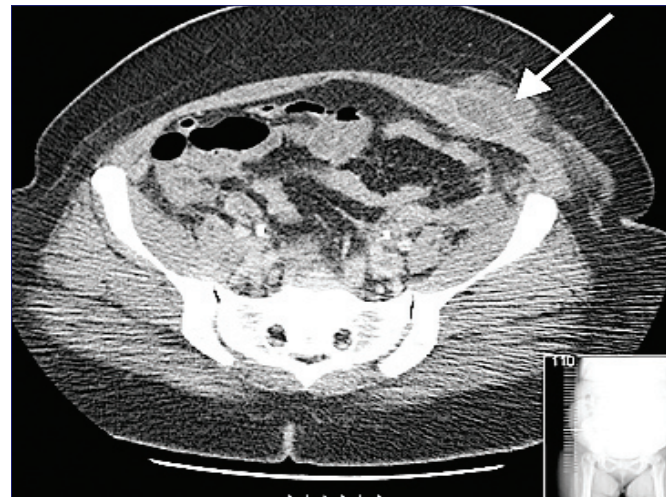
CT without contrast - left abdominal wall collection.
